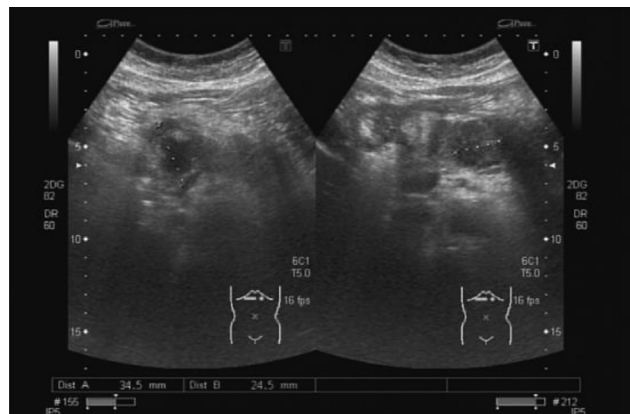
Abdominal sonogram after the first admission. The sonogram shows increased sizes of cystic lesions with irregular wall thickening of the pancreas.
